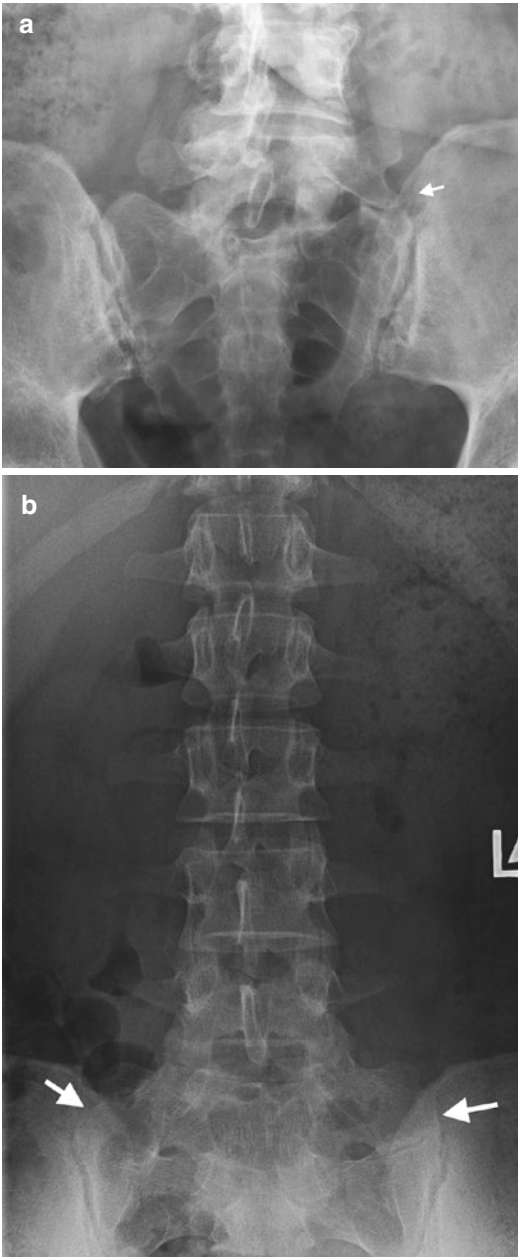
AP radiographs transitional L5 vertebra: (a) type 2A, left synchondrosis (*arrow*) and (b) type 4, left synchondrosis and right-sided fusion transverse process L5 and sacrum (*arrows*)
